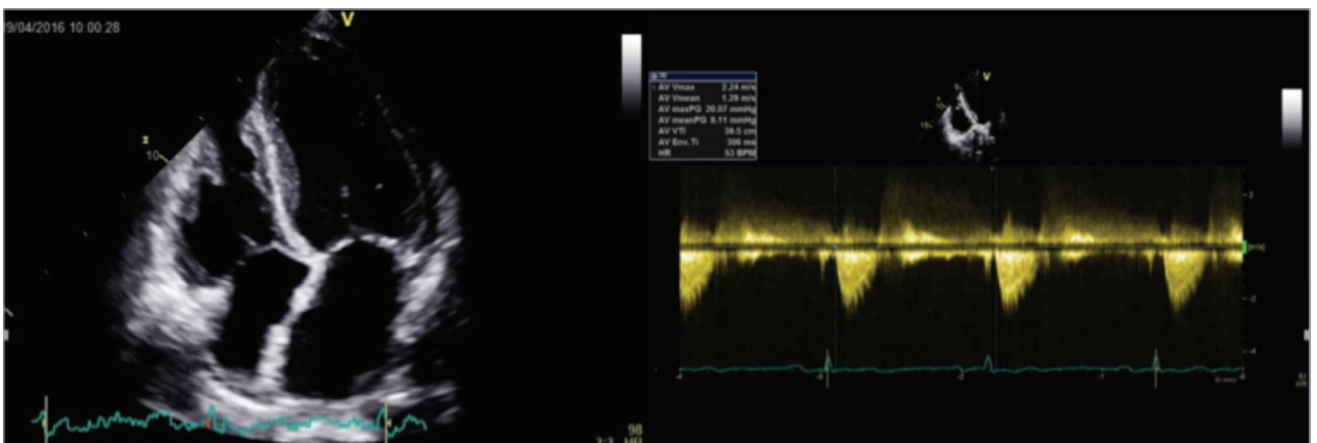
The apical four chamber view and Doppler aortic valve continuous wave after transcatheter aortic valve implantation.
